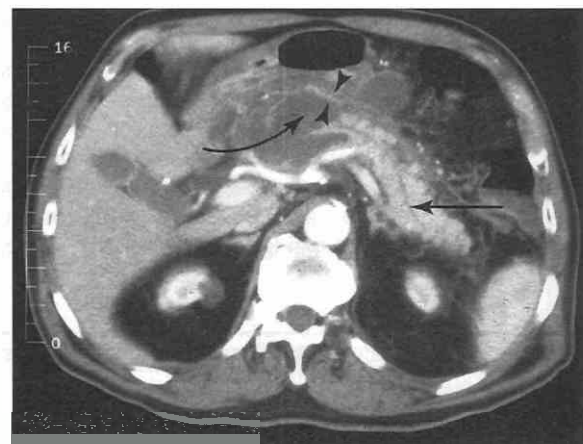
CT scan performed during contrast enhancement shows large fluid mass in the central portion of the pancreas corresponding to an area of necrosis. Dilated pancreatic duct (horizontal arrow) and fluid extension to stomach (curved arrow) can be seen. Gastric wall is distended with inflammatory fluid on both the anterior and posterior surfaces (arrowheads).
